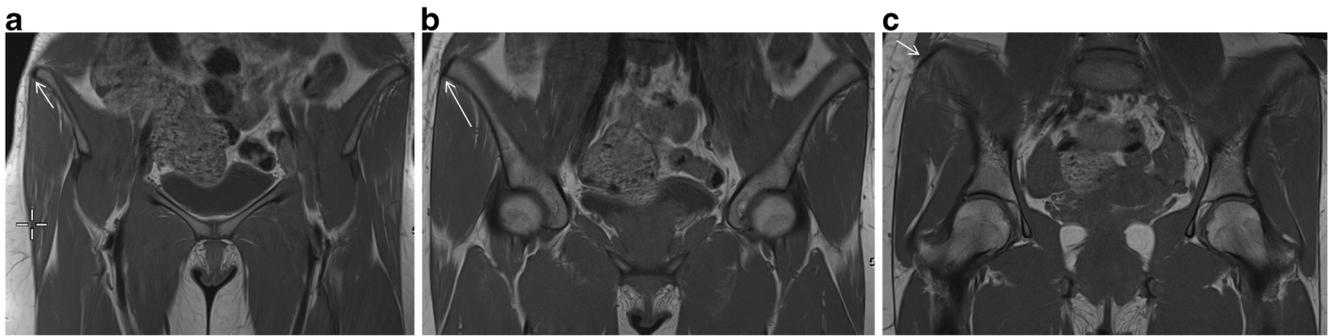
Coronal T1-weighted MRI demonstrates normal anatomy of the FLAIC in a 27-year-old female. a The attachment of the tensor fascia lata and the overlying superficial layer of the iliotibial band are seen along the anterior lip of the iliac crest (*arrow*). The *cursor* marks the fascia lata
